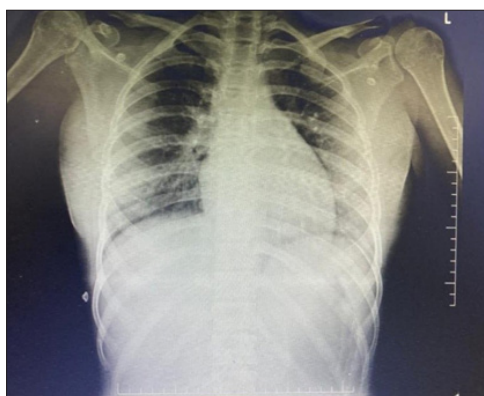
AP View of X-Ray showing Wedge-shaped Opacity on Right Side
